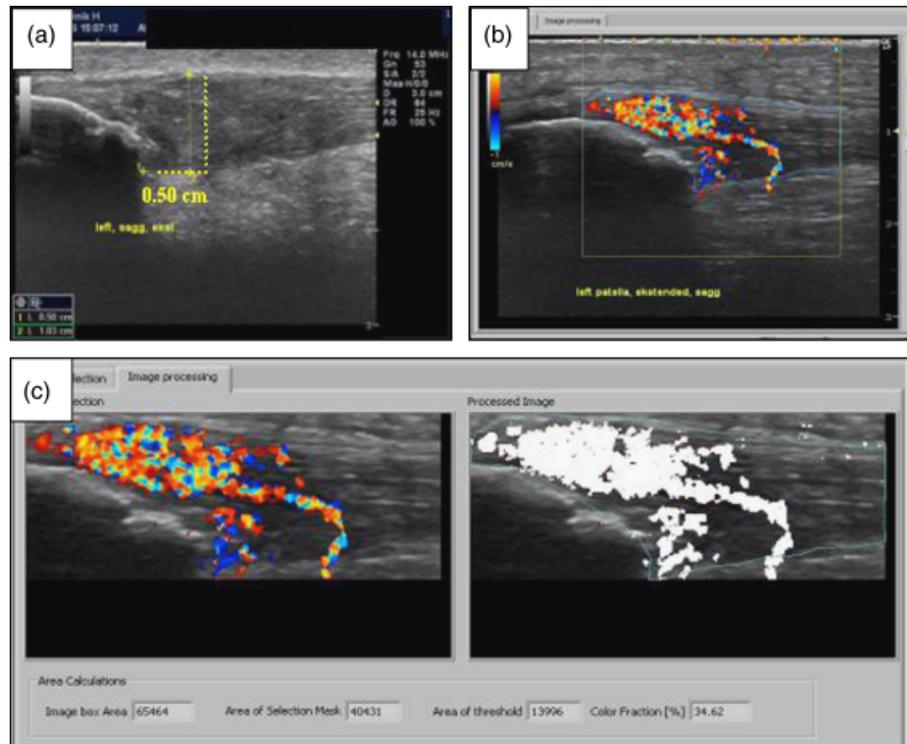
Ultrasonography assessments. (a) Assessment of anterior–posterior patellar tendon thickness. (b) Color Doppler activity recording and (c) software assessment and calculation of color Doppler area.
